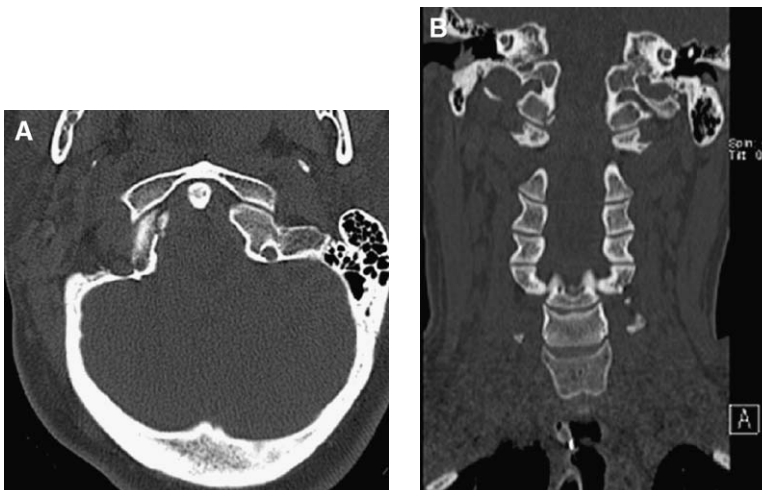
(A and B) Axial and coronal reformatted CT scans demonstrate a mildly displaced fracture of the right occipital condyle.
